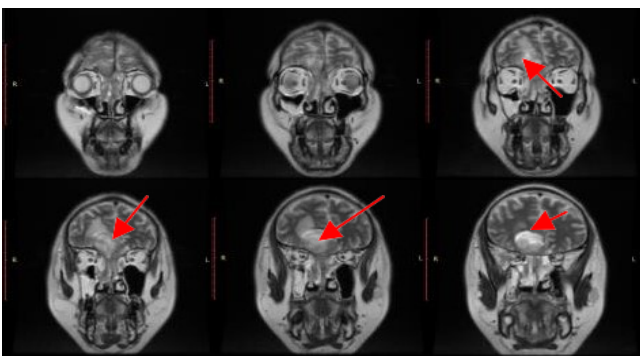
Preoperative coronal brain MRI sequence with contrast on September 22nd, 2022
